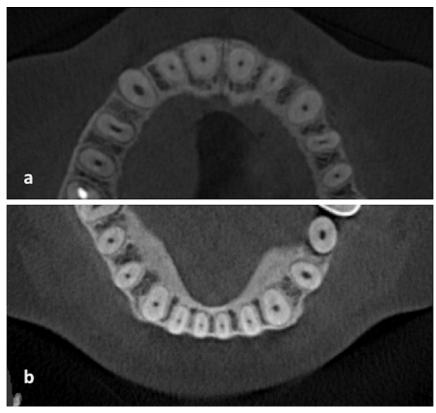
CBCT axial sections showing maxillary (a) and mandibular (b) anterior and premolar teeth with one canal and Vertucci Type I
